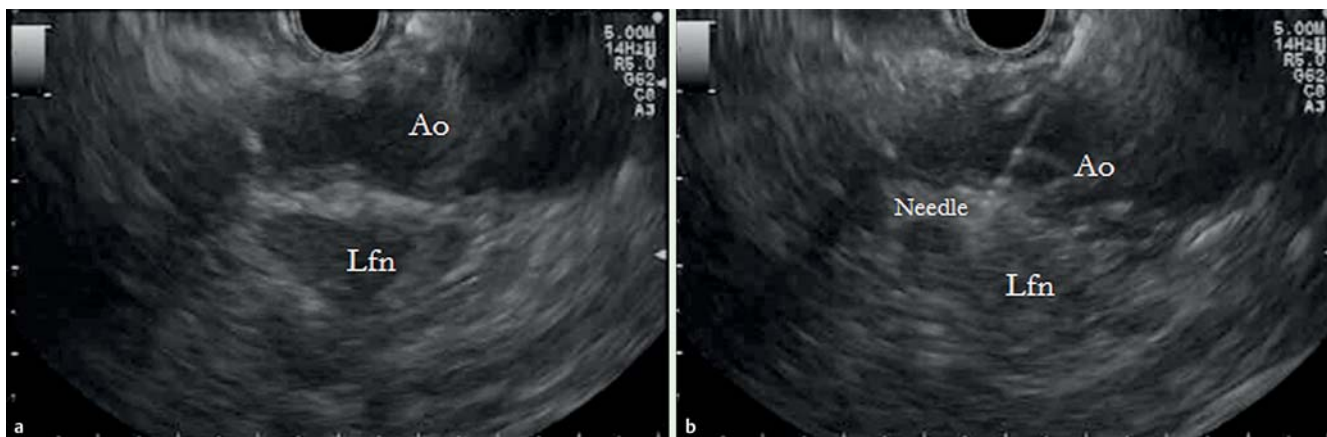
a Endoscopic ultrasound (EUS) imaging of a positron emission tomography-positive lymph node and the interposed aorta in a 73-year-old man previously treated for intrahepatic biliary cystadenocarcinoma. Ao, aorta; Lfn, lymph node. b EUS-guided fine-needle aspiration of the target lymph node with passage of a 25-gauge needle through the aorta. Ao, aorta; Lfn, lymph node.
